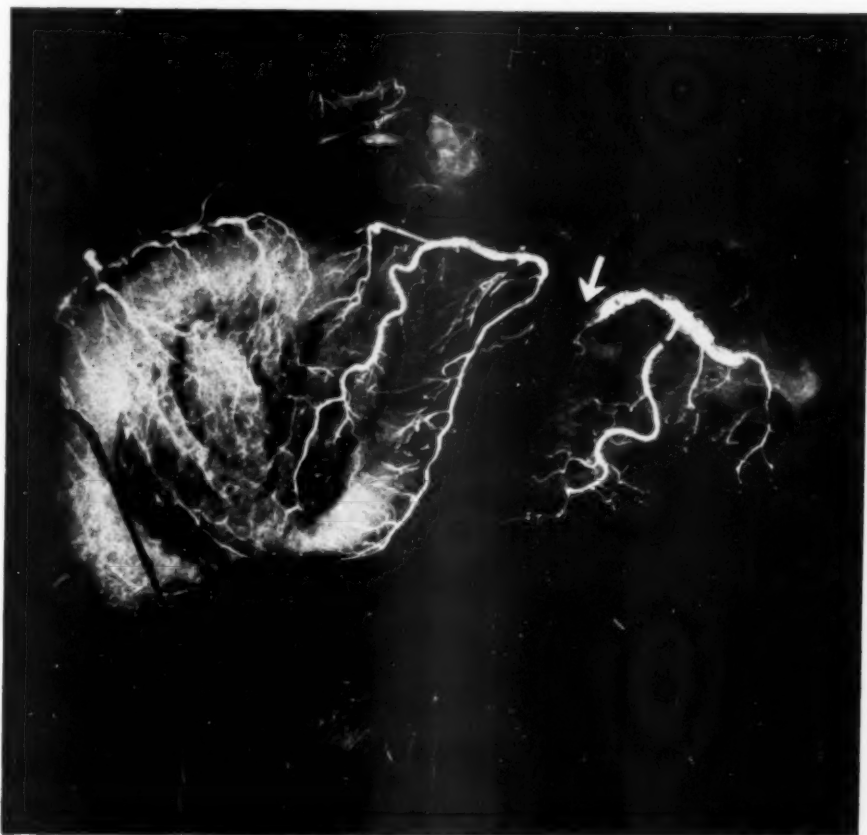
Roentgenogram of the injected heart of Case 2.
